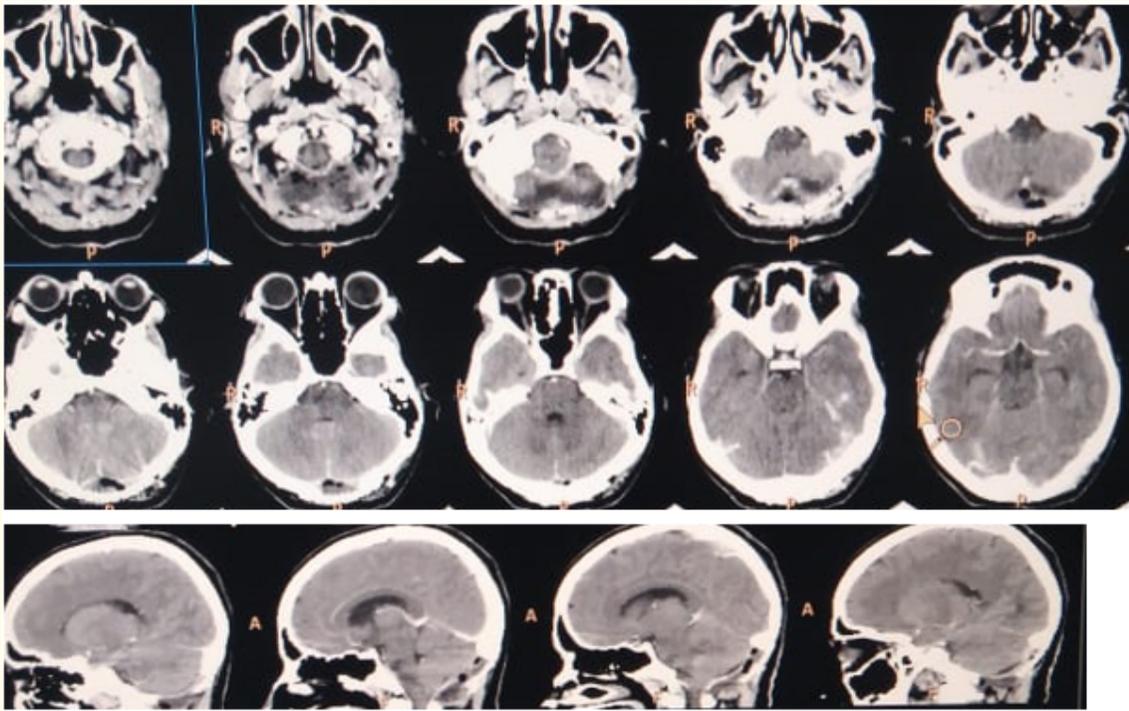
Postoperative CT scan shows complete removal of tumor
